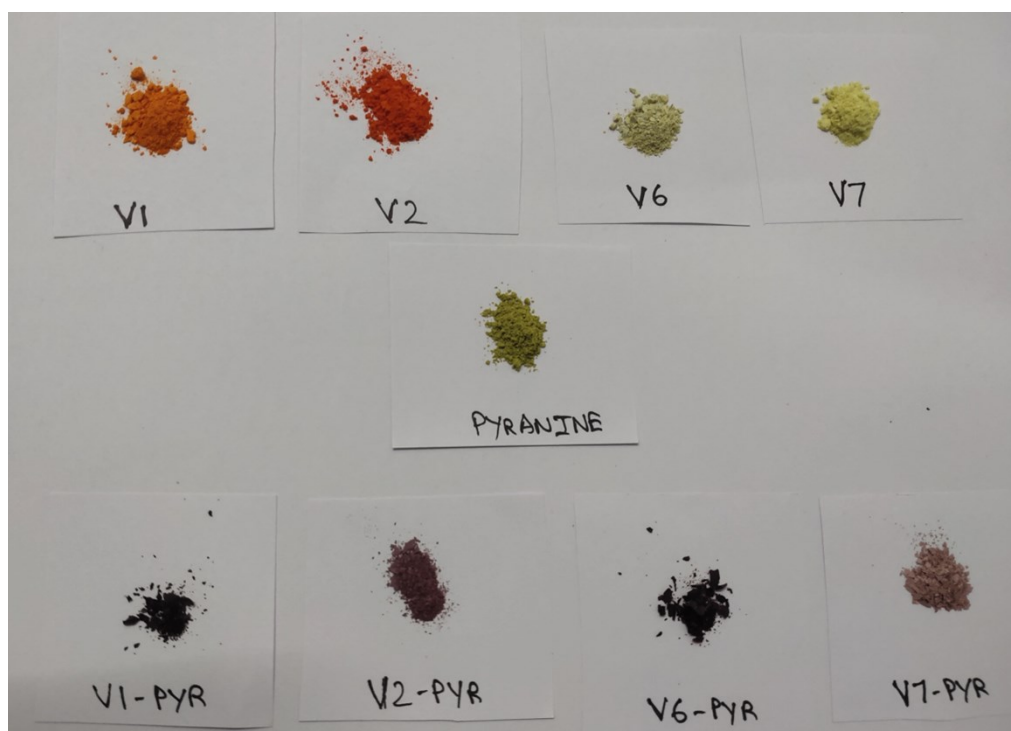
Visual appearance of the viologen derivatives, pyranine and the corresponding CT aggregates after vacuum drying.
